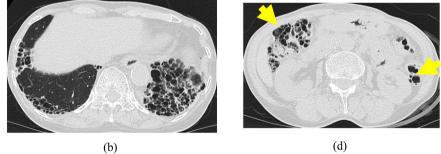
Chest CT ((a) and (b)) showing a nodular shadow with bronchiectatic lesion in the right upper lobe due to pulmonary MAC disease and a linear-reticular shadow in both lower lung fields due to interstitial pneumonia. Abdomen CT ((c) and (d)) showing multiple gas-filled cysts in the intestinal wall (arrows) due to PCI (Case 1).
